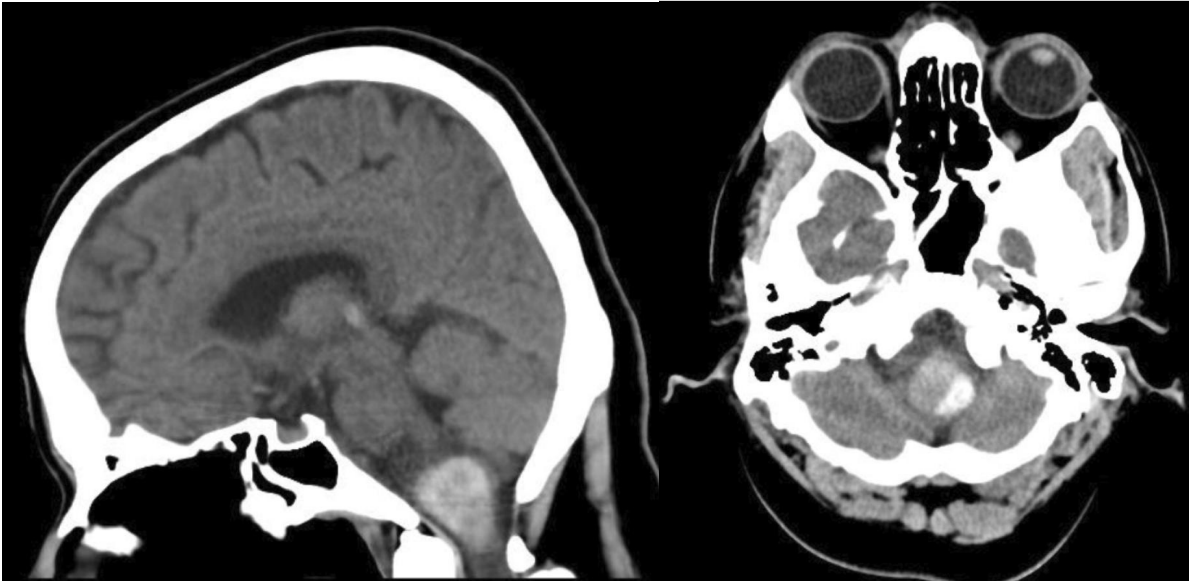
A. Coronal and B. sagittal non-contrast CT images shows well-defined hyperdense lesion in medulla and craniocervical junction with Focal area of increased hyperdensity in left posterolateral aspect of the lesion suggestive of focal hemorrhage.
